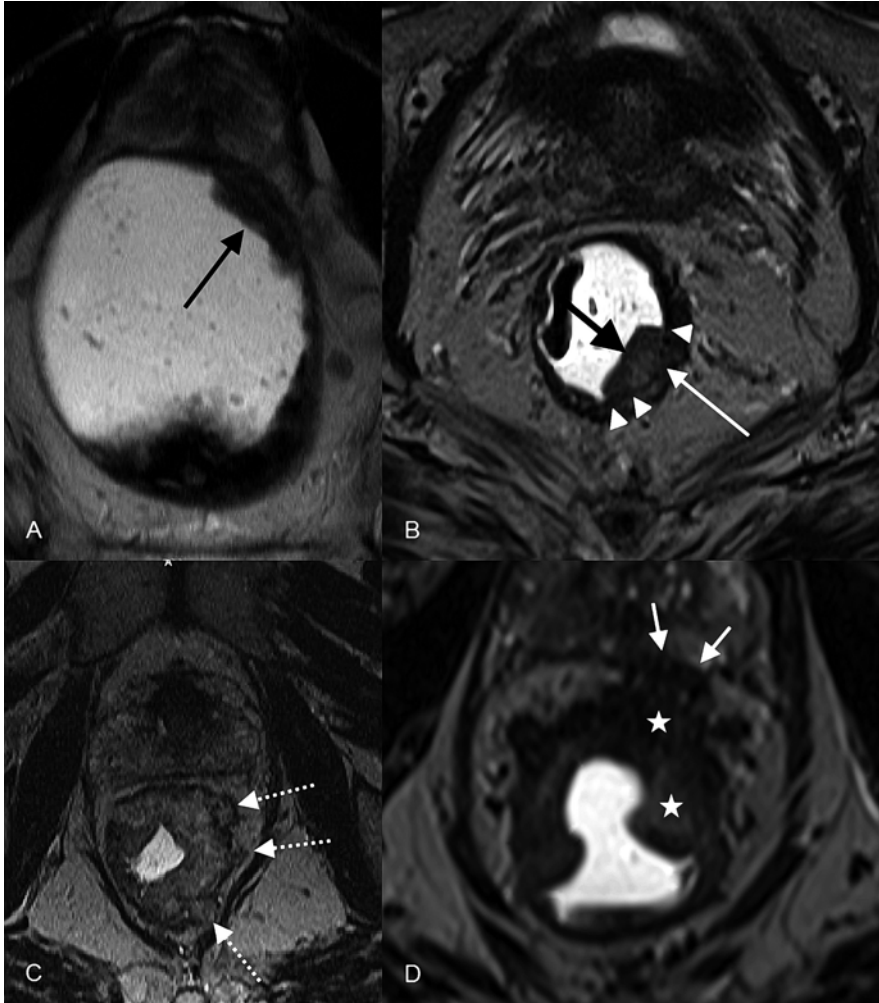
Rectal cancer T-staging. Axial T2-weighted images through the rectum (a) showing a T1 tumor (*black arrow*) without invasion into the rectal wall. (b) A T2 tumor (*thick black arrow*) disrupting (*white arrow*) the rectal mucosa (*white arrow head*). (c) A T3 tumor with nodular extension into the mesorectal fat (*white dashed arrows*). (d) A T4 tumor (*white stars*) extending through the mesorectal fascia into the prostate (*short white arrows*)
